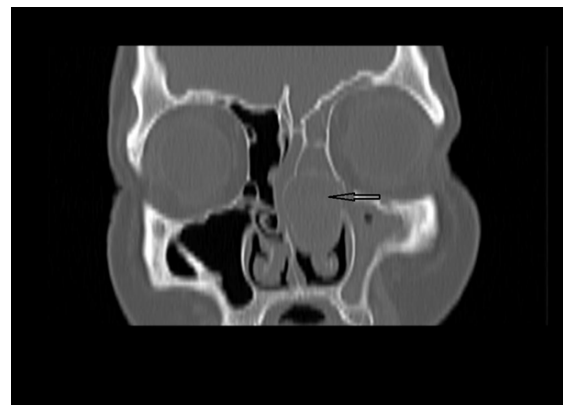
Image of the mass completely filling the left nasal cavity in the paranasal CT section.
